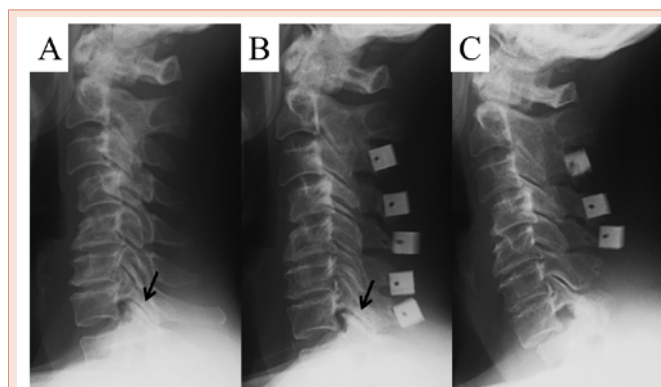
Plain radiography before laminoplasty (A), three years after laminoplasty (B) and seven days after second surgery. (C). This view shows facet joint osteoarthritis at C7-T1 three years after laminoplasty, which was not present preoperatively (arrow). The hydroxyapatite spacers on the spinous process at C6 and C7 were removed, and laminectomy from C6 to T1 was performed.
